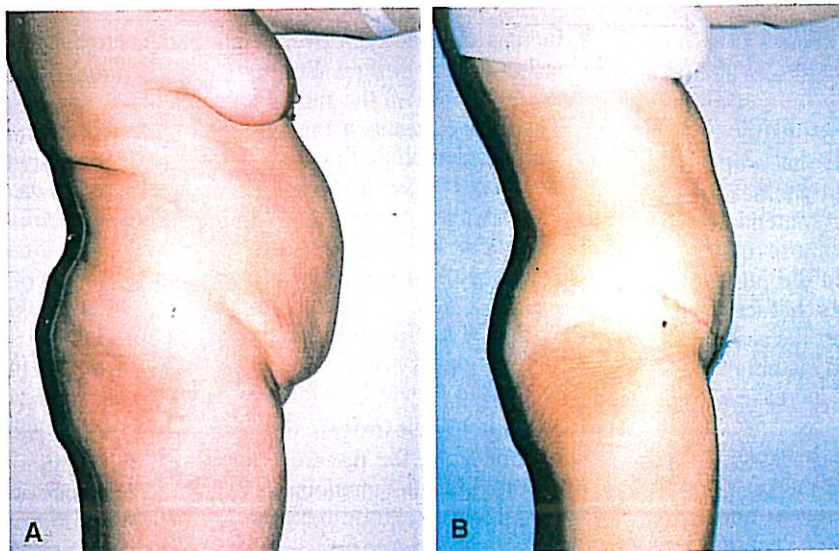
A 55-year-old patient. Results 6 months after abdominal dermolipectomy and liposculpture by ultrasound on the abdomen, sides, and thighs. Extraction of 3.5 liters of fat; operation followed by 12 weekly Endermologie sessions. Total weight loss: 17 kg.
